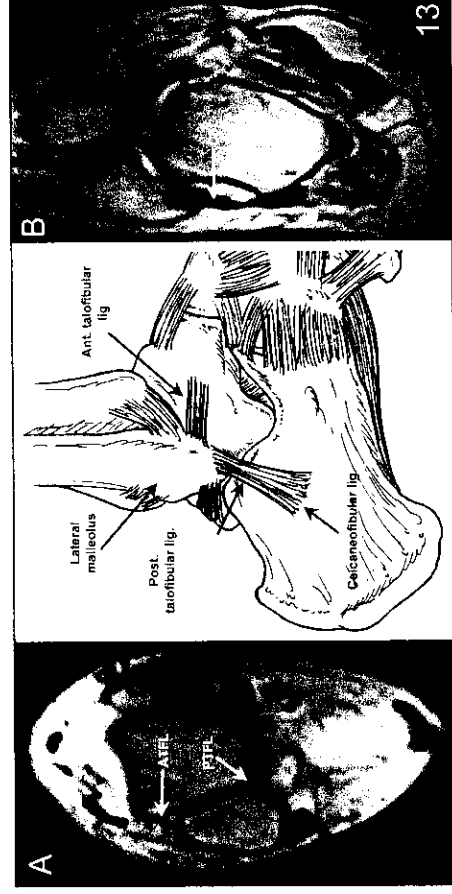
Picture and MRI scan image (A, B) of the lateral ligament. A: Anterior talofibular ligament (ATFL) and posterior talofibular ligament (PTFL); B: Calcaneofibular ligament (CFL).
